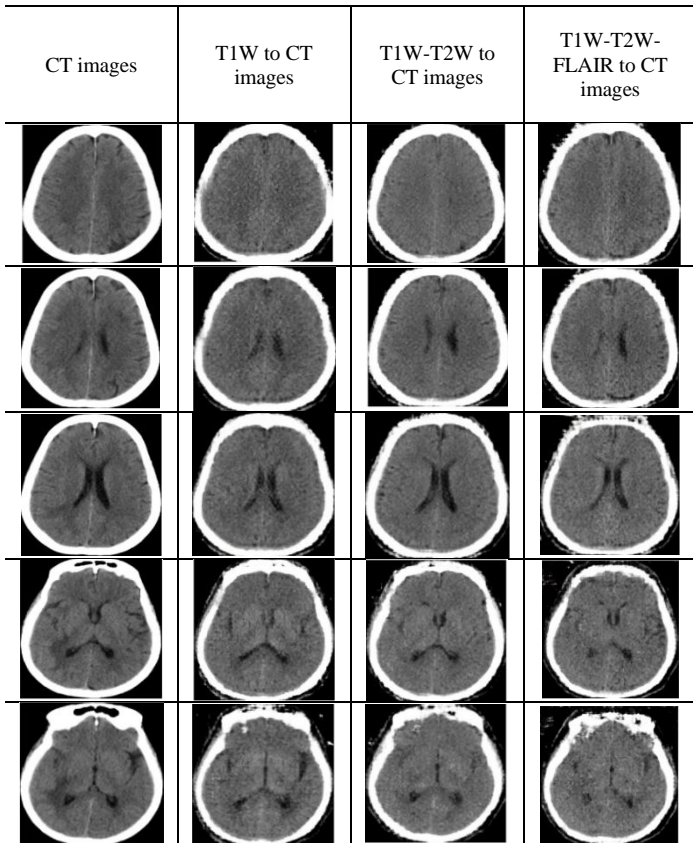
Sample translation results of Patient#1. The actual CT images (1st column), translated CT images from T1W (2nd column), T1W-T2W (3rd column), T1W-T2W-FLAIR images (4th column).
